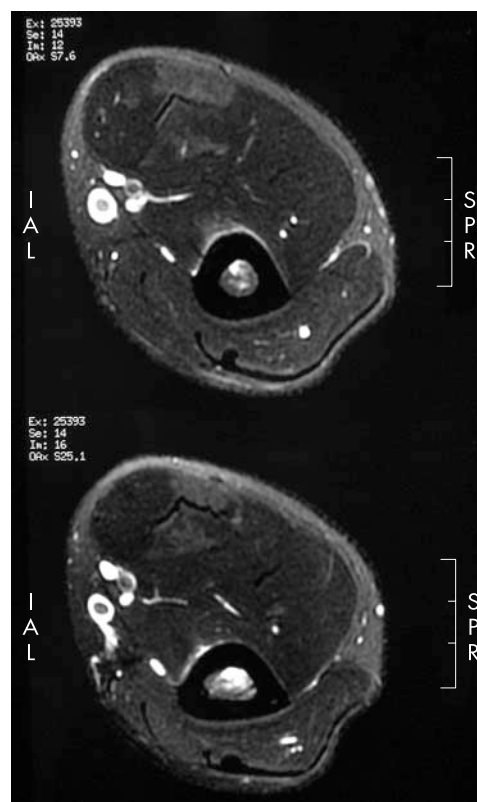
MRI STIR axial images showing the liquid in the periosteum and a mild medullary oedema in the distal humerus. Patient consent has been obtained for publication of this figure.
